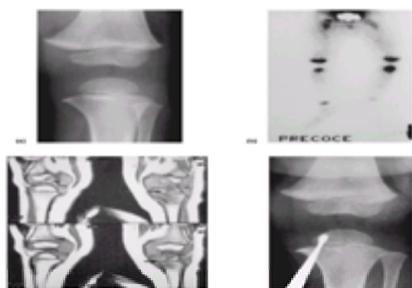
Acute osteomyelitis in a 2-year-old boy. (a) Plain film: medial radiolucent area in the tibial metaphysis. (b) Bone scan: increased uptake in the upper left tibia. (c) T_1 -weighted MR images confirm the previous findings and show the extension of the infection through the growth plate in the epiphysis (arrow). (d) Perioperative plain film confirms the MR findings.
